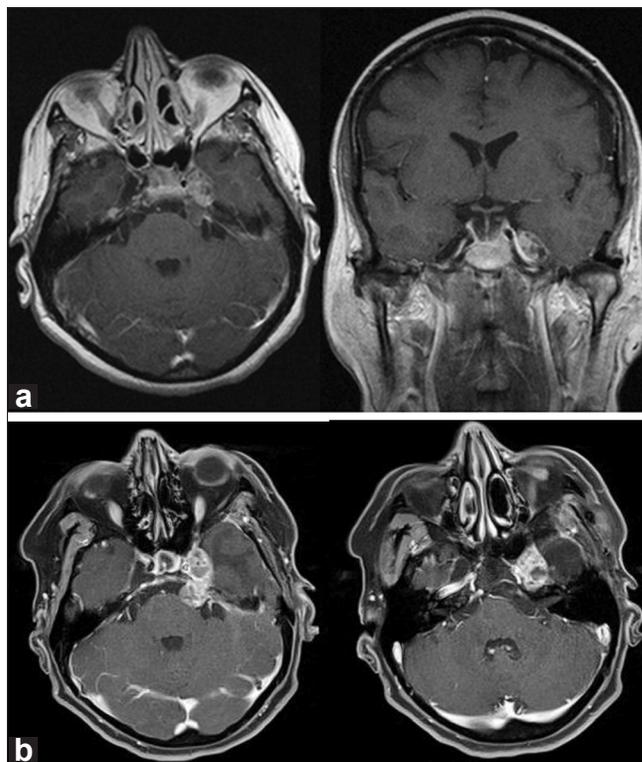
(a) The first manifestation of the tumor. The axial and coronal T1-weighted, contrast-enhanced MR scan shows a strongly enhanced lesion in the Meckel’s cave. The large tumor is compressing the prepontine cistern, the pontocerebellar cistern and the pons. A clear border among the tumor, trigeminal nerve and the internal cerebral artery is indistinguishable. (b) Pre-operative axial T1-weighted MRI with contrast media revealing the first reoccurrence of the tumor in the left Meckel’s cave. The volume of the tumor in the medial fossa is approximately 2.5 × 1.8 cm. Regressive changes and cystic compartment with liquid mirror image are visible within the lesion. Part of the tumor is located in the posterior fossa; its volume is 1.3 × 1.6 cm. The left trigeminal nerve inside the tumor is no longer distinguishable. Additionally, a compression of the pons as well as the left cerebral peduncle in the ponto-mesencephalic junction can be seen. The part of the tumor in the middle fossa has contact with the C2–C5 segments of the left internal carotid artery
